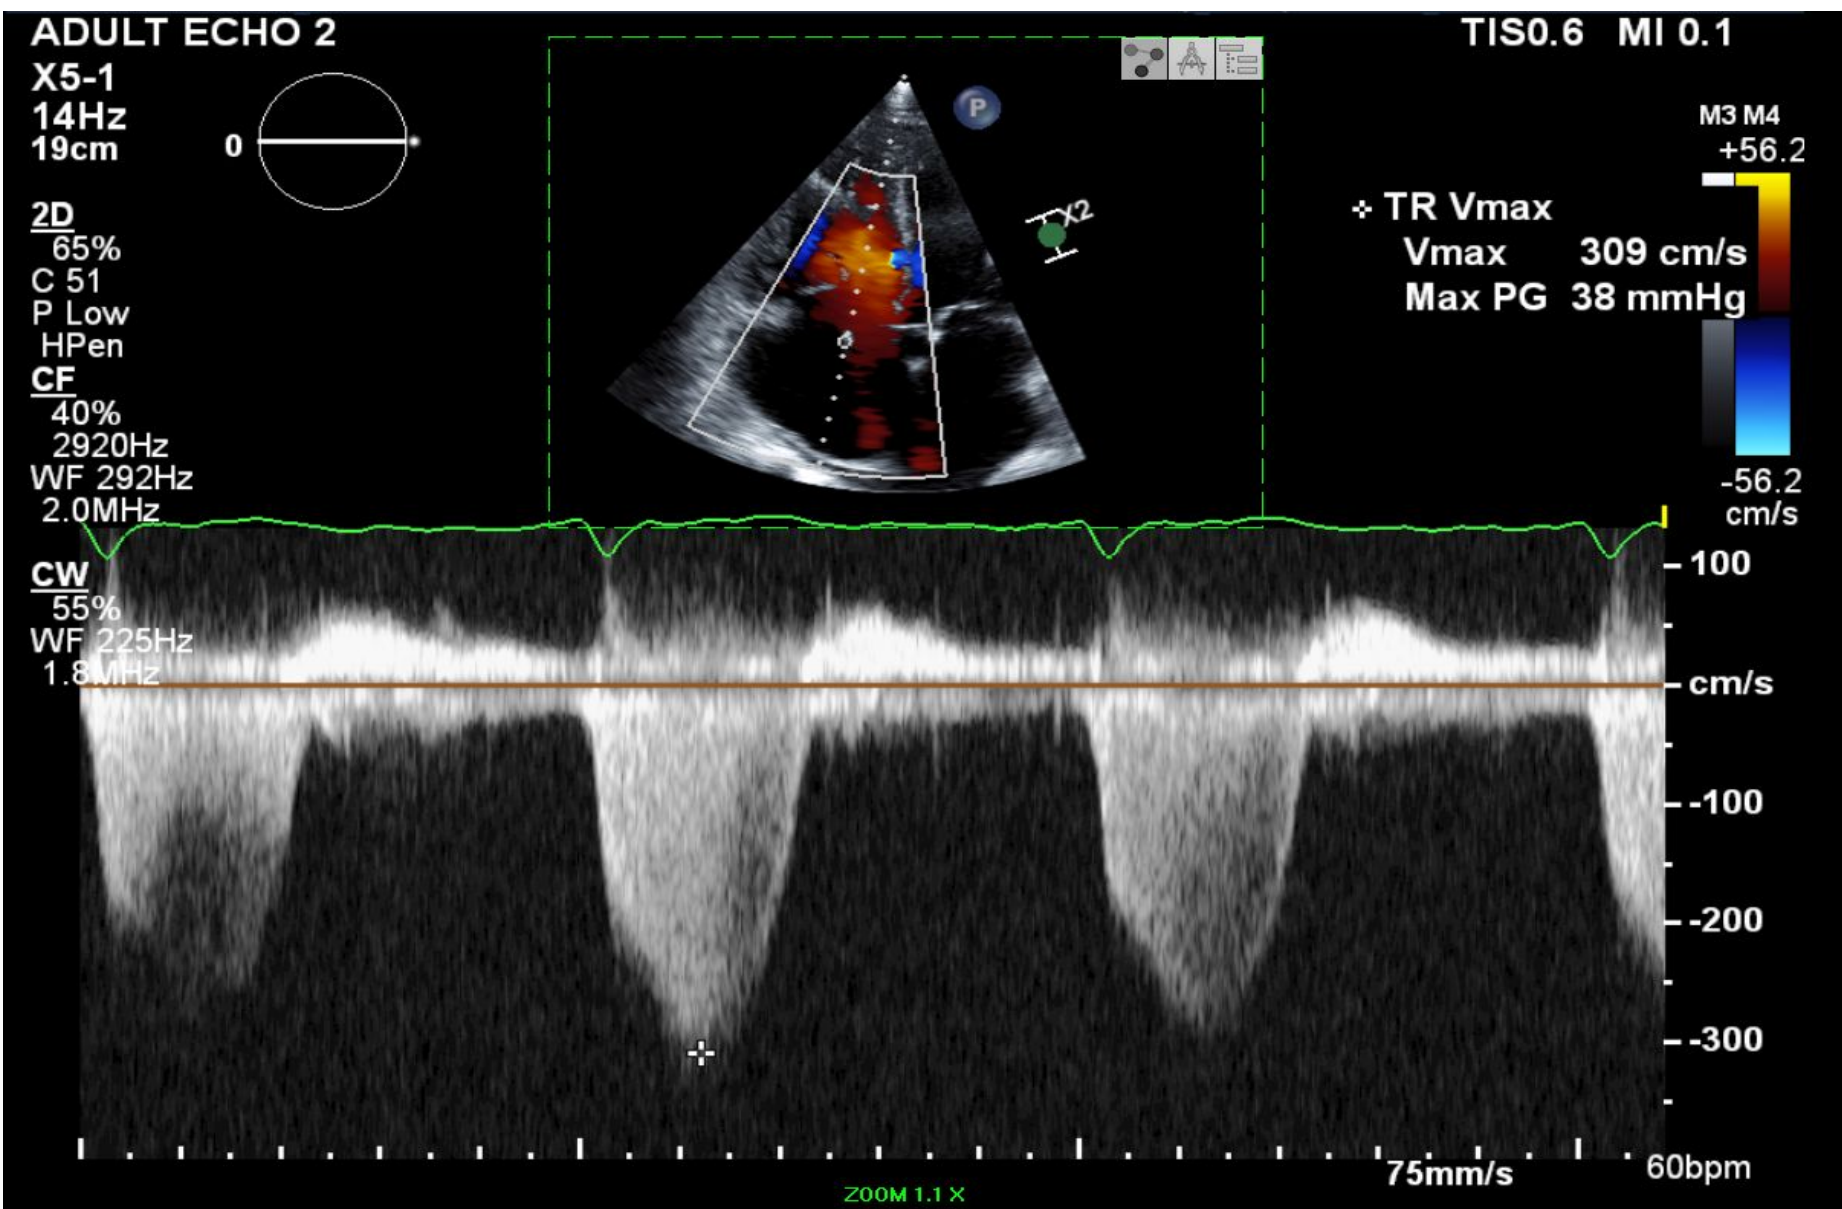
Echocardiogram: apical four chamber view shows moderate tricuspid regurgitation (TR), TR peak gradient of 38 mmHg (reference range: <35 mmHg) and TR peak velocity of 309 cm/s (reference range: <280cm/s).
